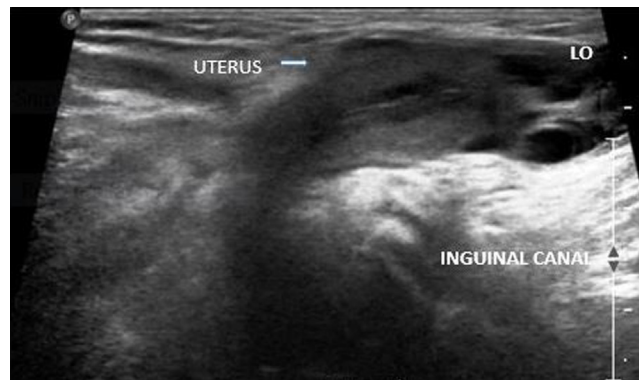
Ultrasonography of the left groin reveals herniation of uterus into the inguinal canal.
